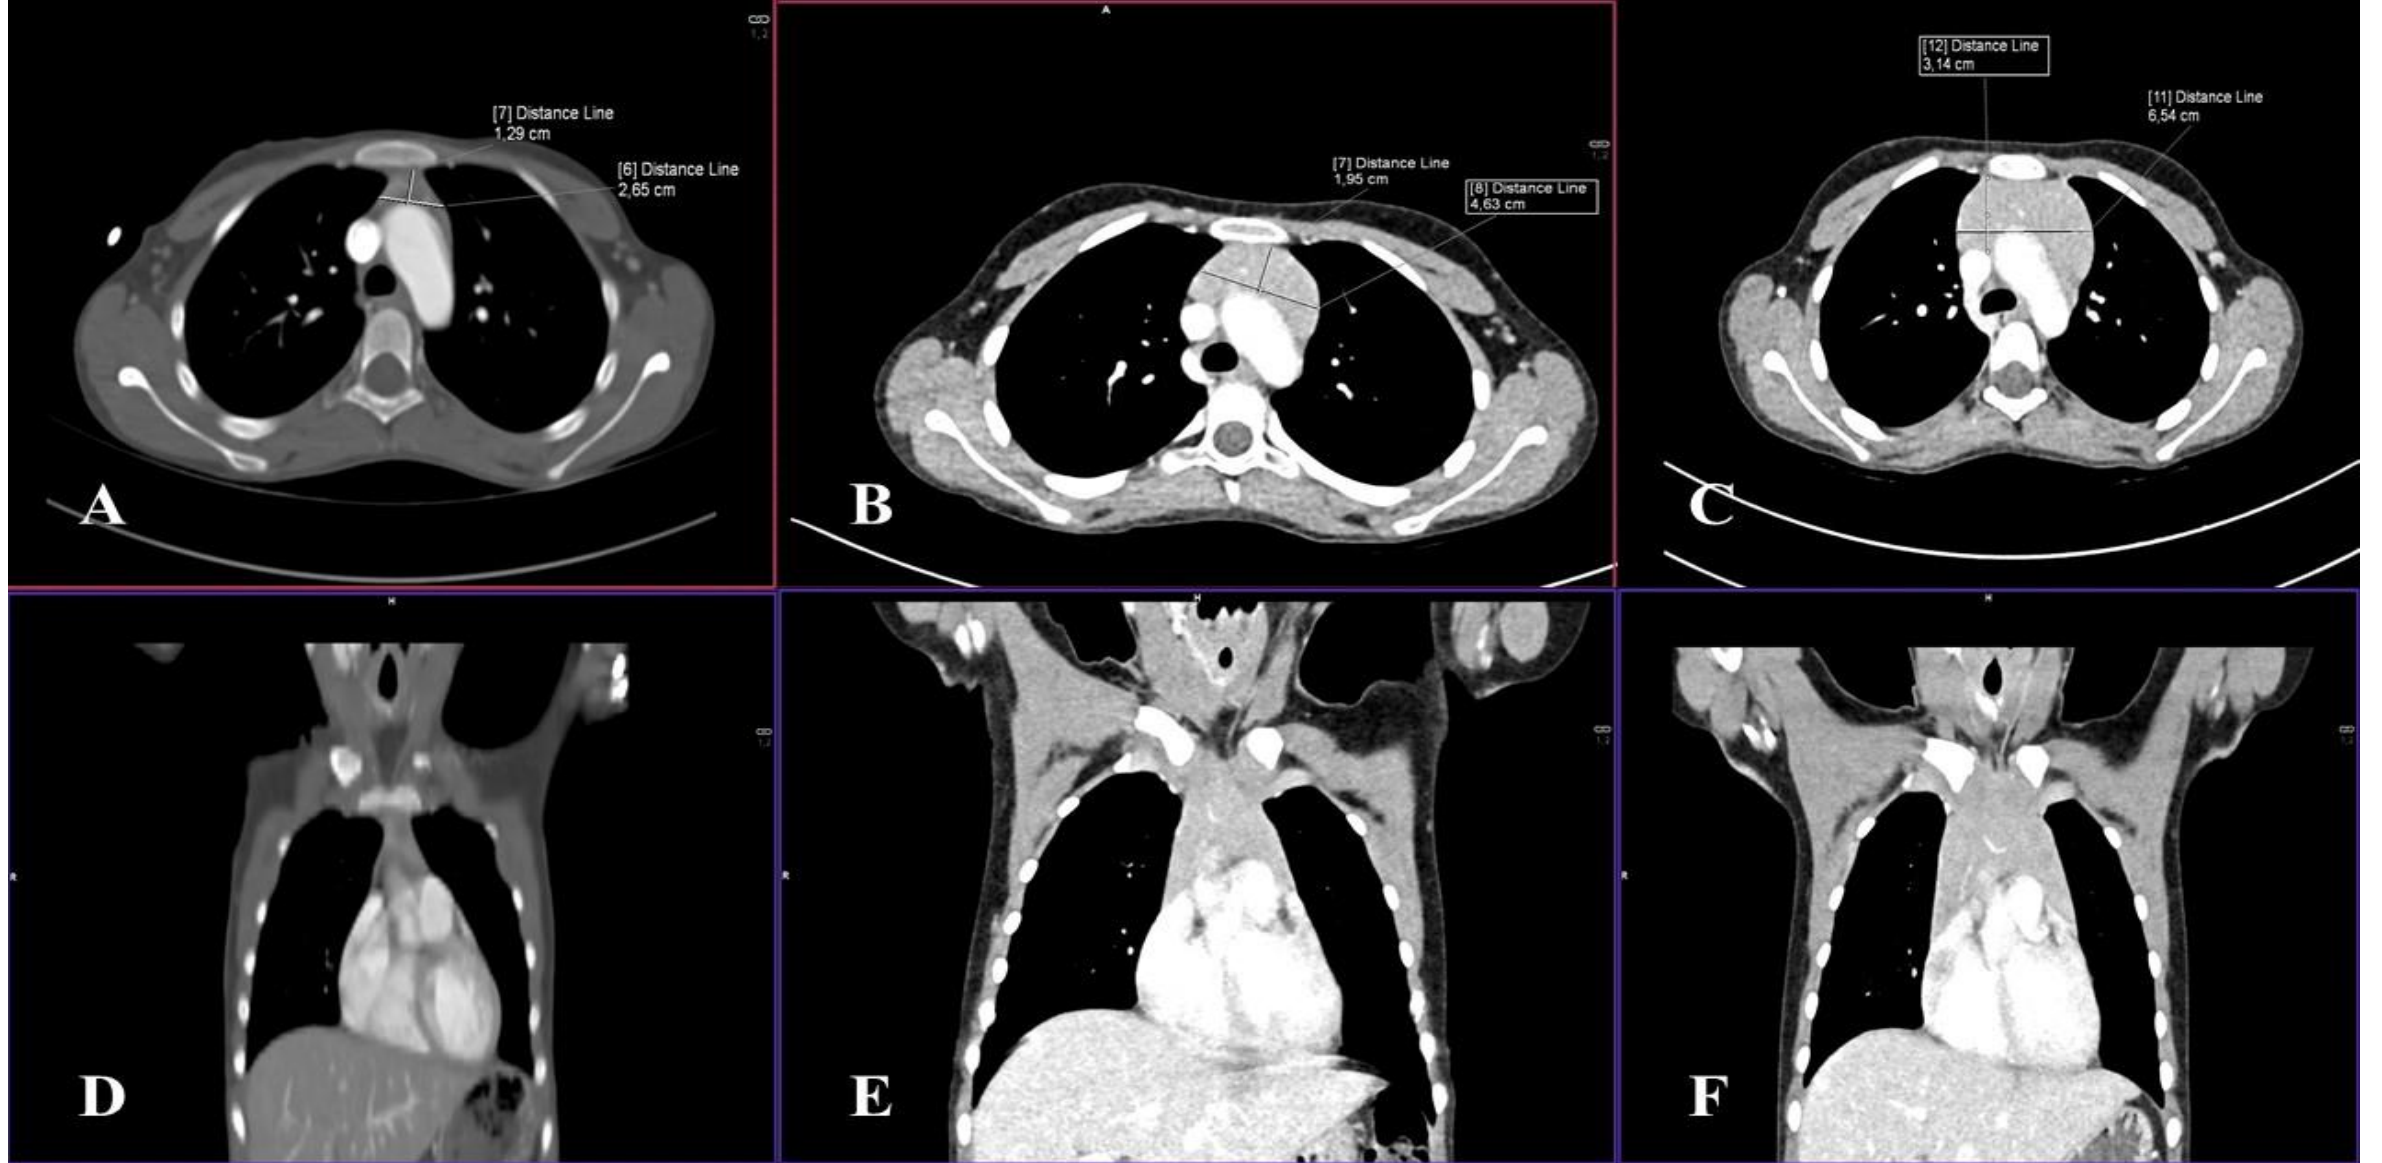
"Coronal CT images (A and D), axial and coronal CT images at 15 months post-operation (B and E), and axial and coronal CT images at 24 months post-operation (C and F)."
